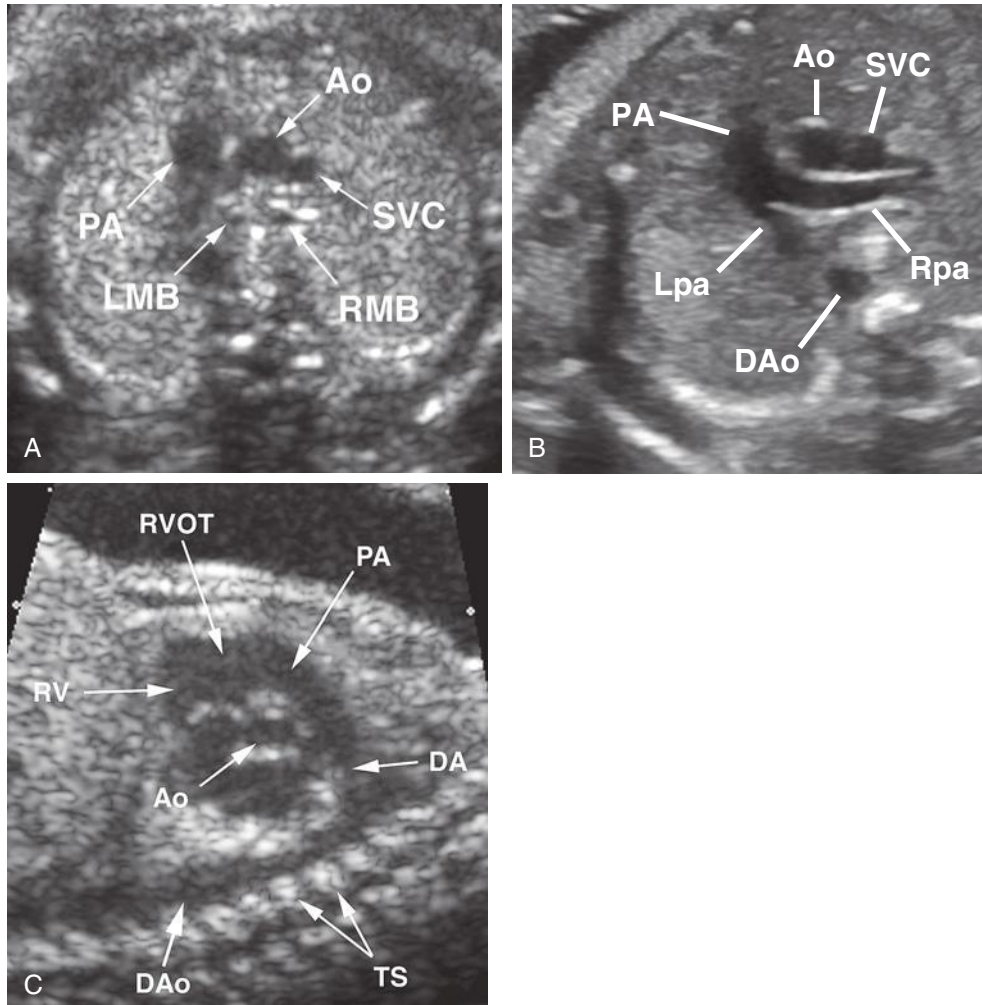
A and B, Transverse axial sonograms through the fetal chest. C, Midsagittal sonogram of the fetal chest. In transaxial sonograms (A and B) the great vessels lie sequentially from right to left and posterior to anterior as follows: superior vena cava (SVC), aorta (Ao), and pulmonary artery (PA). The descending aorta (DAo) lies immediately anterior to the thoracic spine (TS). The right pulmonary artery (Rpa) passes directly posterior to the aorta and superior vena cava. The right (RMB) and left (LMB) mainstem bronchi lie posterior to the great vessels. DA, ductus arteriosus; Lpa, left pulmonary artery; RV, right ventricle; RVOT, right ventricular outflow tract.
